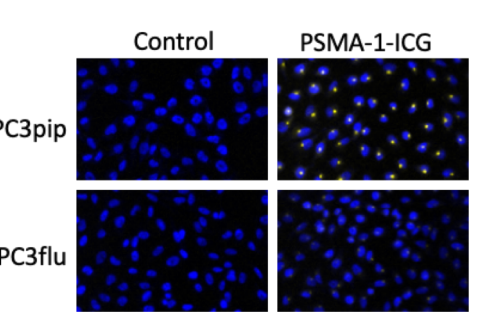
PSMA-1-ICG is selectively taken up by PSMA positive cells
